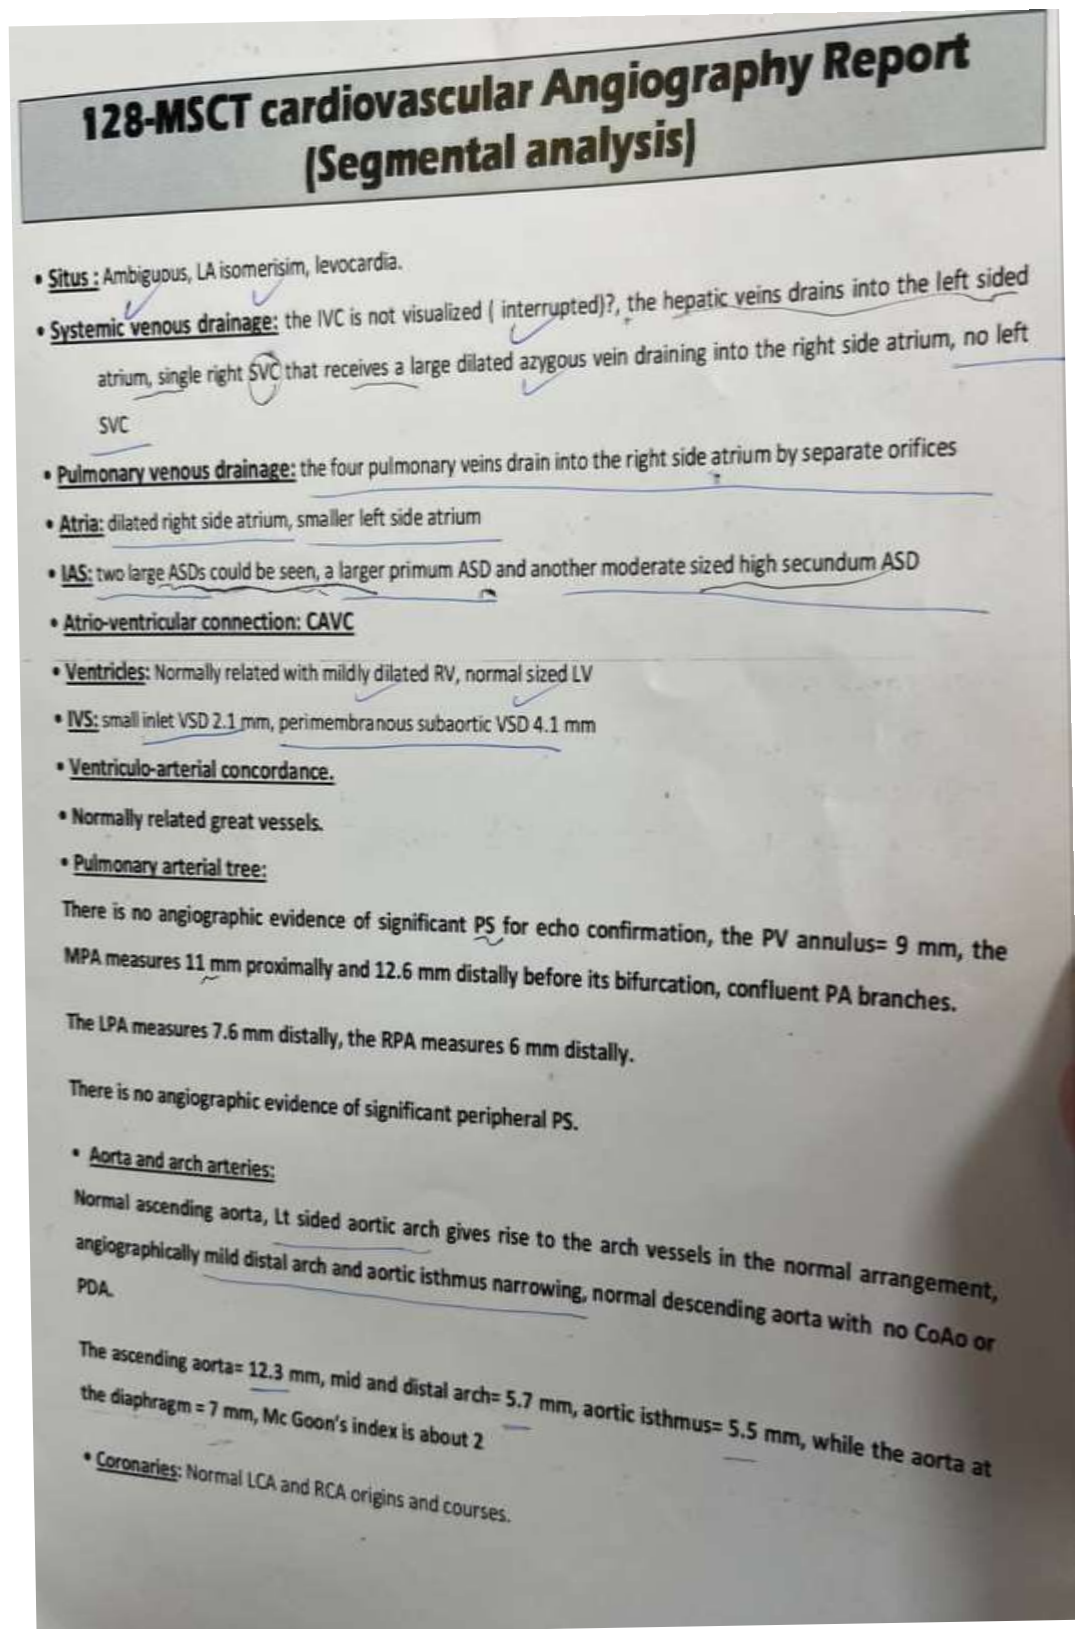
Computed tomography (CT) of the chest showing finding of CT
